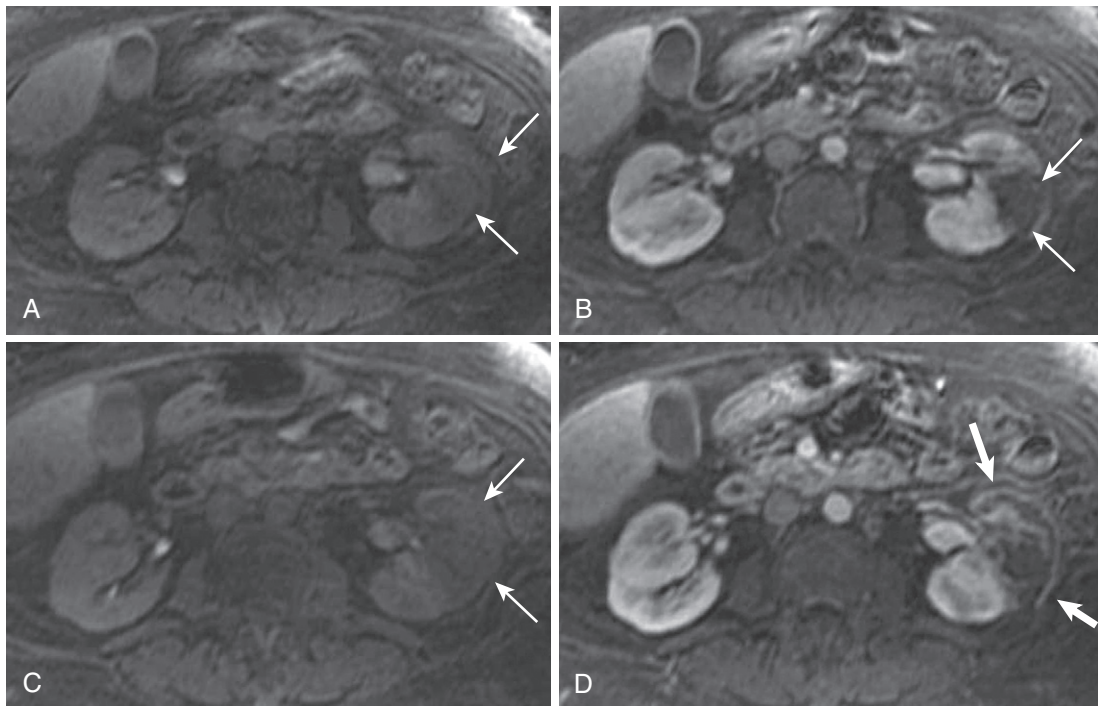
Renal infarct. The precontrast T1-weighted image (A) shows a sharply demarcated wedge-shaped lesion in the anterior interpoler aspect of the left kidney (arrows), clearly delineated by adjacent enhancing renal tissue on the postcontrast image (B) due to the lack of enhancement. Similar features (thin arrows in C) on adjacent sections (precontrast [C] and postcontrast [D]) with the cortical rim sign on the enhanced image (thick arrows in D).
